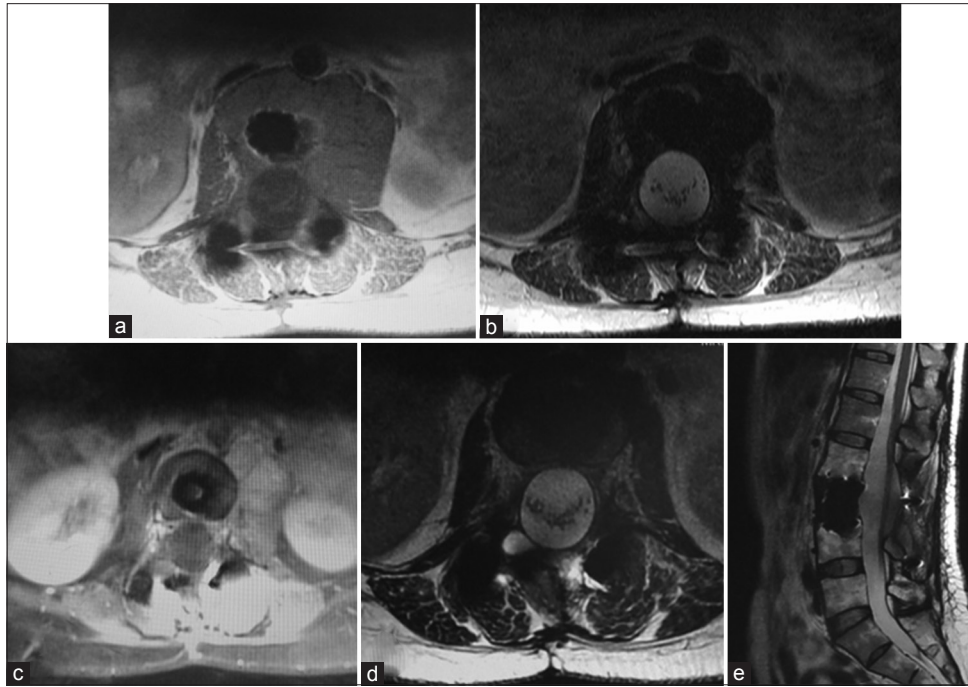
A 35-year-old female underwent intensity-modulated arc therapy (60 Gy/2.7 Gy/22 fractions) for an L3 giant cell tumor after recurrence. She underwent intralesional curettage with local recurrence. (a-c) Axial magnetic resonance image (T1, T2, and T2 with contrast, respectively) after local recurrence showing bilateral paravertebral masses. (d and e) Axial and sagittal magnetic resonance image at the 36-month follow-up, respectively.
